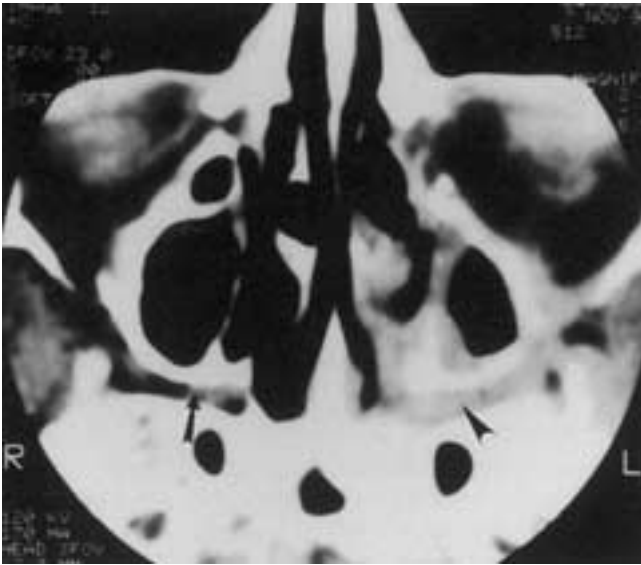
Axial CT image showing adenoid cystic carcinoma following the second division of the trigeminal nerve. The tumor (*black arrowhead*) obliterates the fat in the pterygopalatine fossa. Compare this with the fat (*arrow*) on the normal side.
